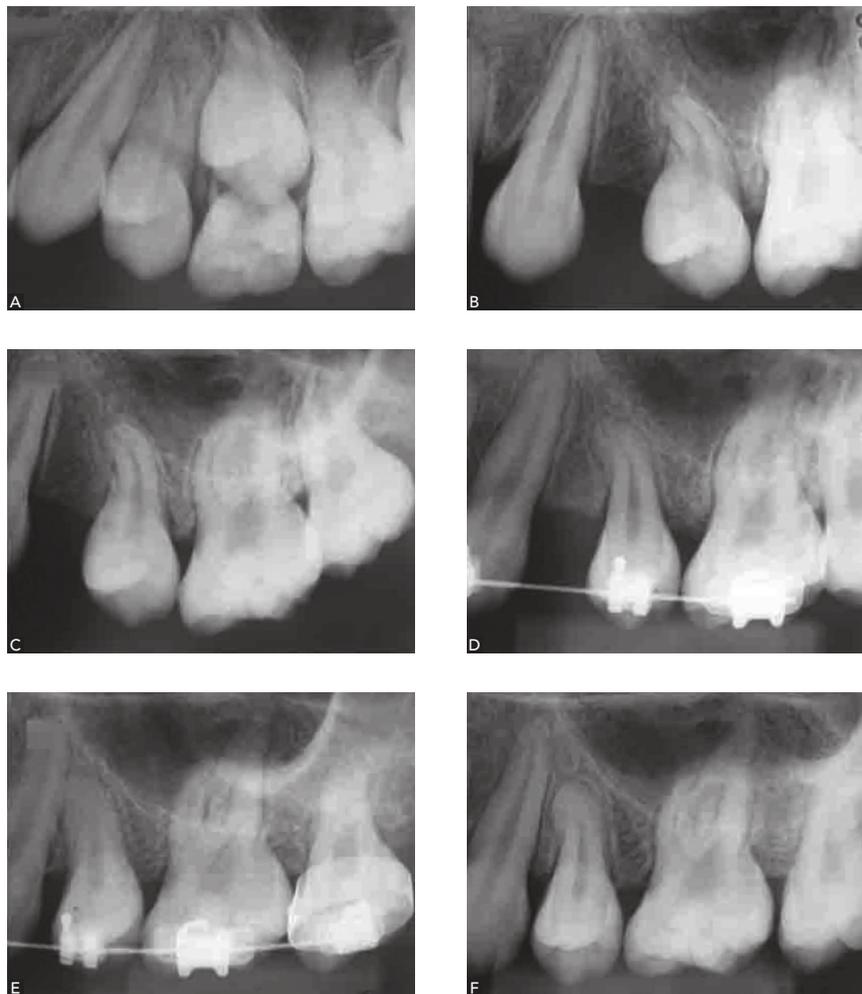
Radiographic sequence of upper second premolars with short root anomaly (SRA). A) Mixed dentition indicating the early stages of SRA; B) before, C) during and D,E,F) after orthodontic movement, showing relative control of external apical root resorption.
